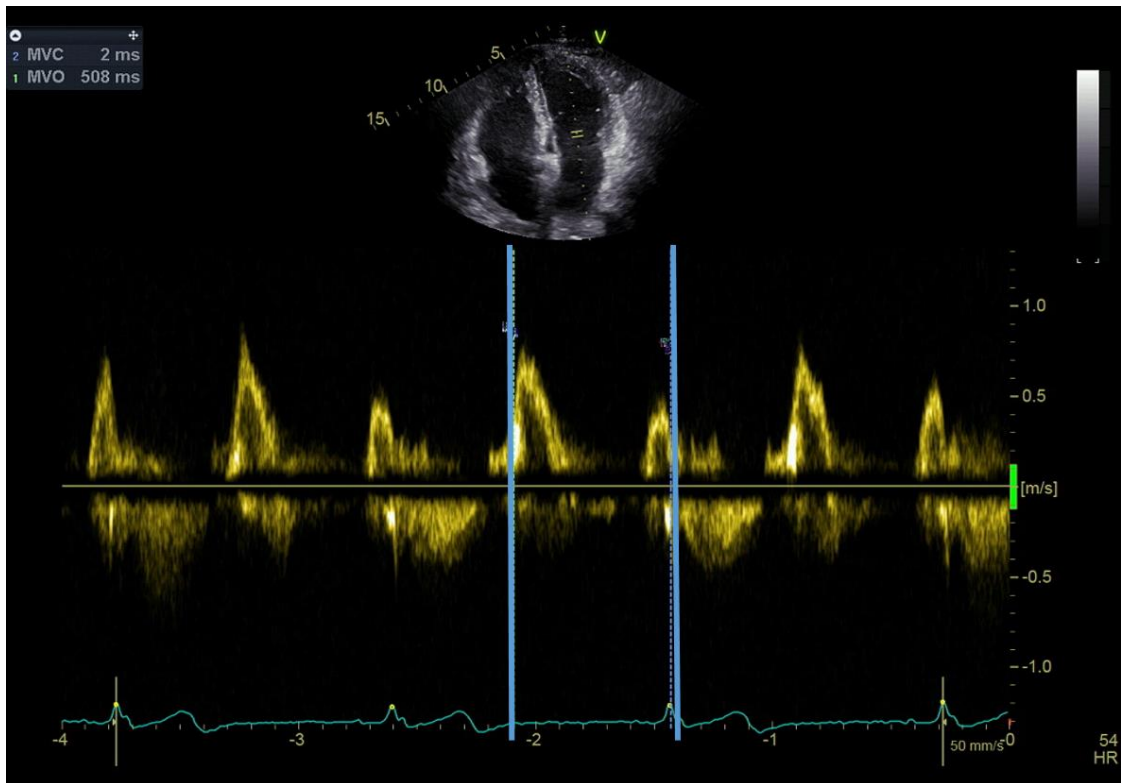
First, using pulsed-wave Doppler in apical 4-chamber view, mitral valve closure and opening times are tracked.
